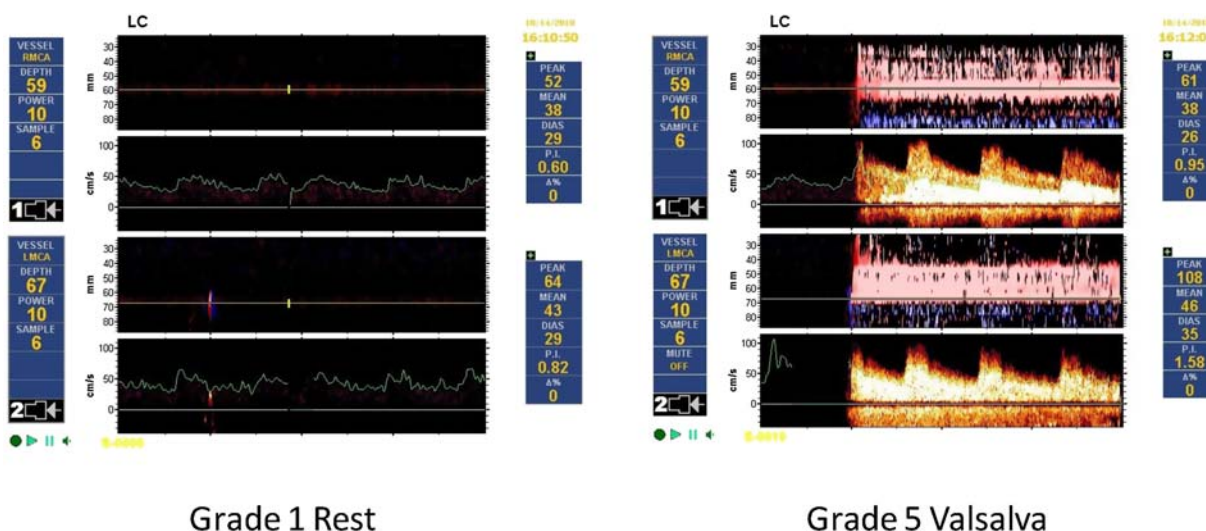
Transcranial Doppler grading with microembolic signals that measure the degree of right-to-left shunting ranging from grade 1 (left) to grade 5 (right).
